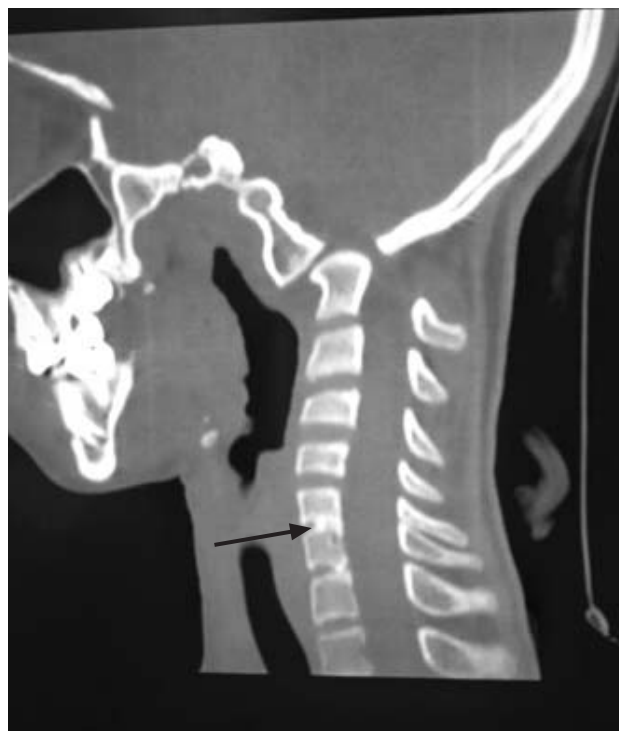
CT Sagittal reformat- Wasp- Waist Sign (Reduced AP diameter of the vertebral bodies).
